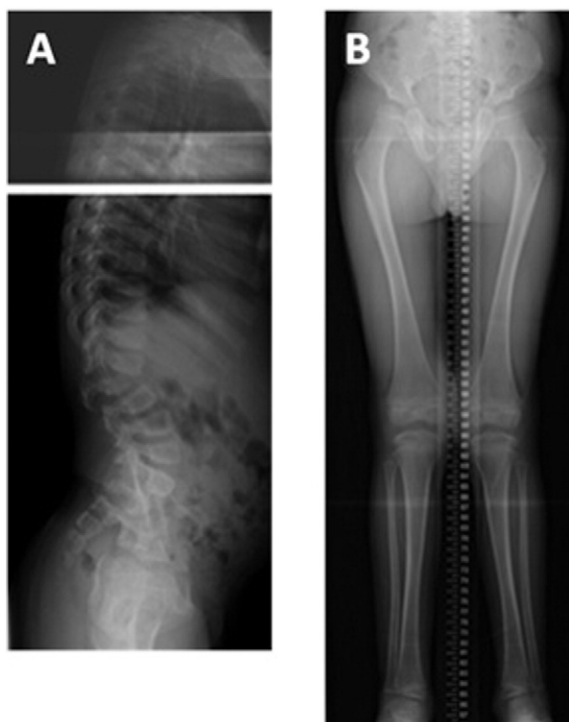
X-rays at 6.5 years of age. Diffuse bony changes consistent with dysostosis multiplex. A) Kyphotic deformity (gibbus) at the thoracolumbar junction due to hypoplasia of L2. B) Bilateral genu valgum. No leg length discrepancy is noted.
